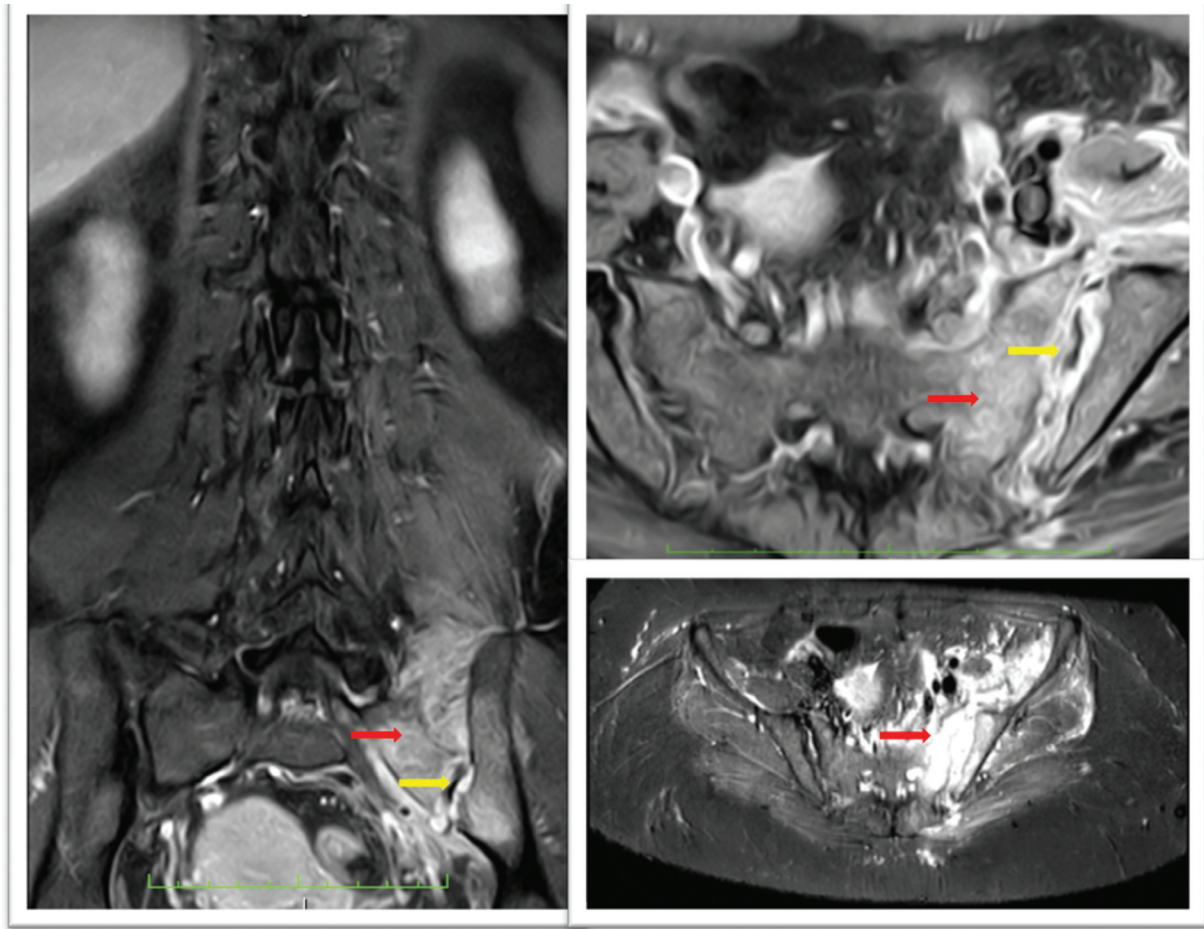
Coronal (left) and axial (T1-STIR) magnetic resonance imaging scan of the left sacroiliac joint (left), showing irregularity and loss of definition of the subchondral compact bone on both joint surfaces, with erosive phenomena on the bone surfaces (yellow arrows), joint effusion, and accentuated edema of the sacral and iliac spongy paraarticular bone tissue (red arrows).
